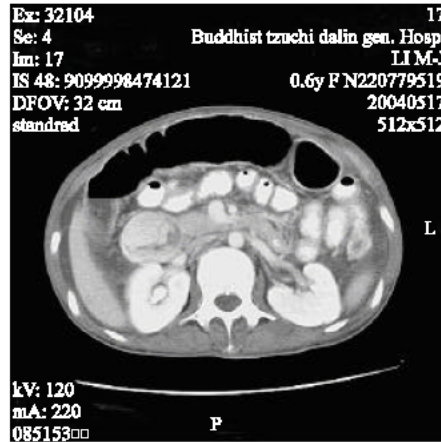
Thick duodenal wall was identified in the abdominal CT
